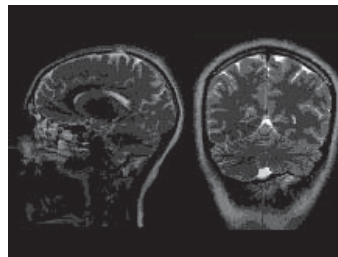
MRI Brain showing a Depressed fracture of occipital bone. They are Linear, Stellate or
